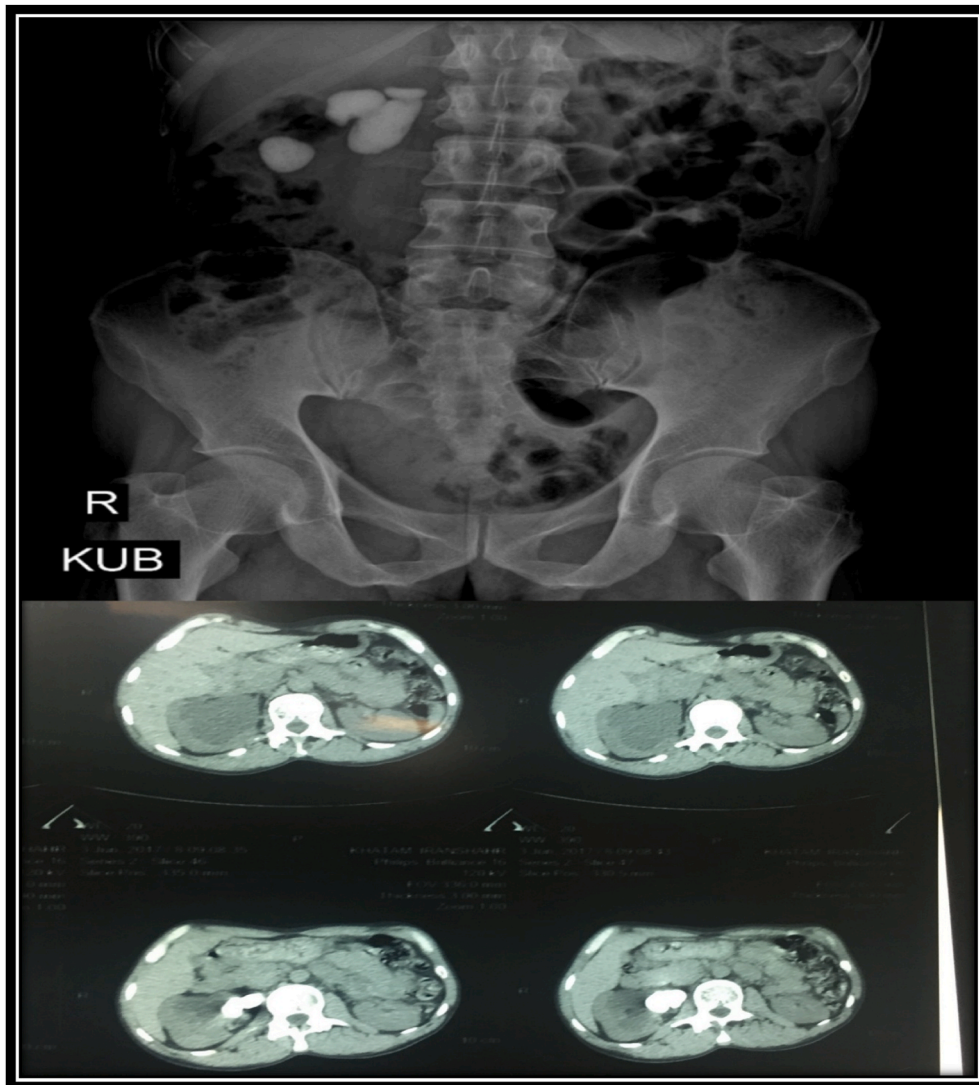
CTscan & x-ray image of the KUB that showed stone in right kidney.
